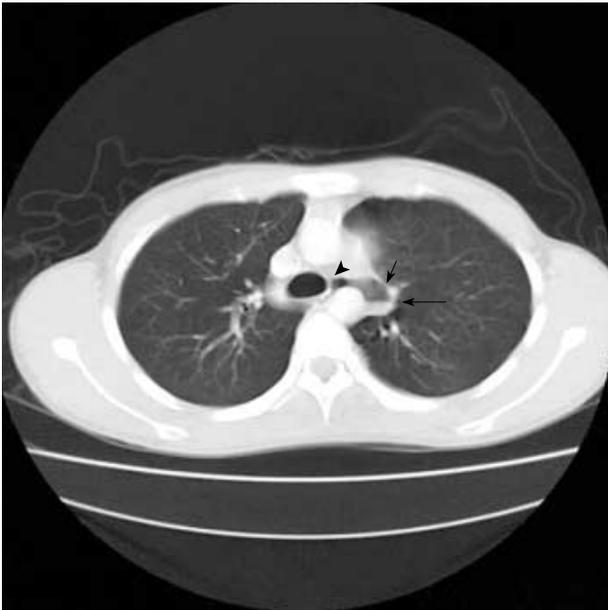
Axial chest CT on lung setting shows a cyst (short arrow) with an air-fluid level (long arrow) abutting the esophagus by tubular structure (arrow head) in the aortopulmonary window.
